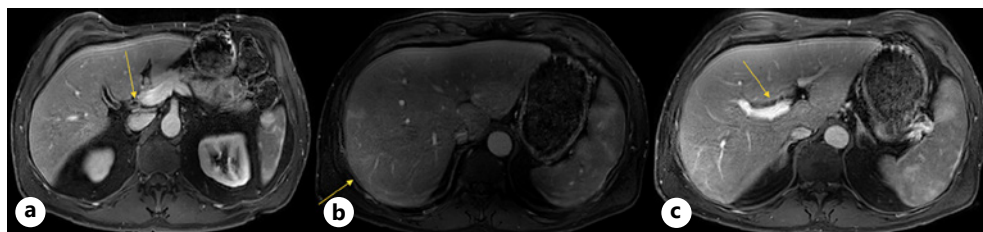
T1-weighted, contrast-enhanced images from the patient's MRI abdomen with contrast MRCP. a Wall enhancement of the common bile duct, suggestive of cholangitis. b Mild peripheral heterogeneous hepatic parenchymal enhancement, consistent with hepatitis. c Periportal edema, consistent with hepatitis.
